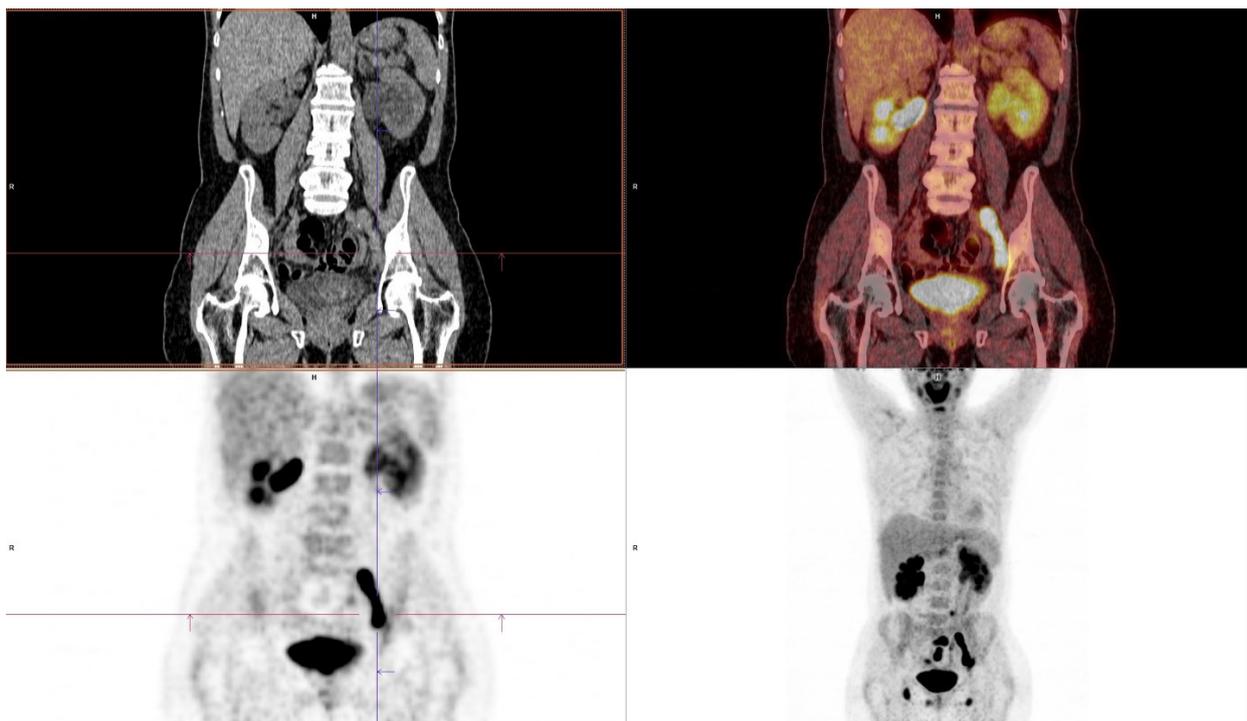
Coronal plane of unenhanced low dose CT, PET, fused PET/CT and MIP (maximal intensity projection). Increased uptake in left iliac lymph nodes and in regional bones.
